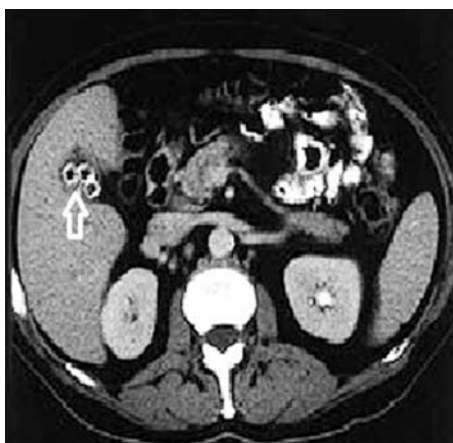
CT scan of the upper abdomen showing multiple gallstones (arrow)*
